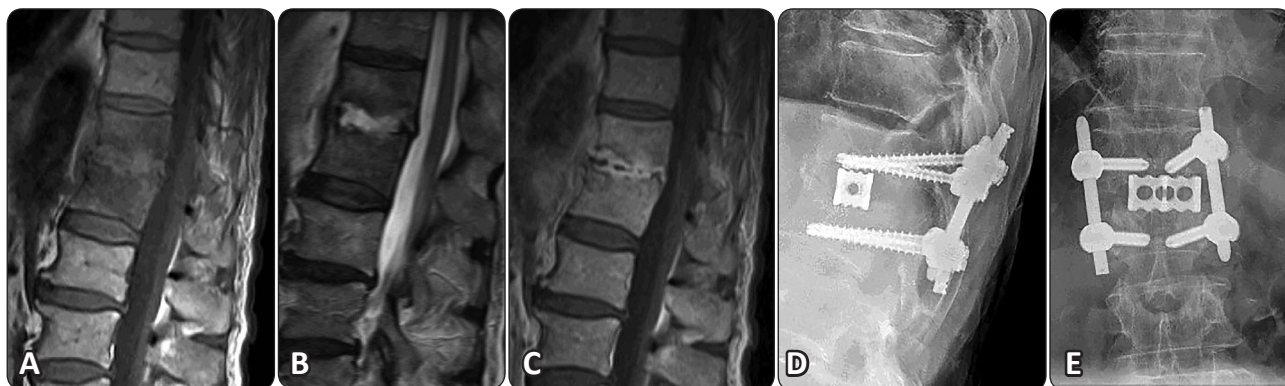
Preoperative MRI sagittal Images of Spondylodiscitis Th11/12 (A) T1 sequence (B) T2 Sequence (C) T1 with contrast injection. Postoperative AP (D) and lateral (E) radiographs one year postoperative.
